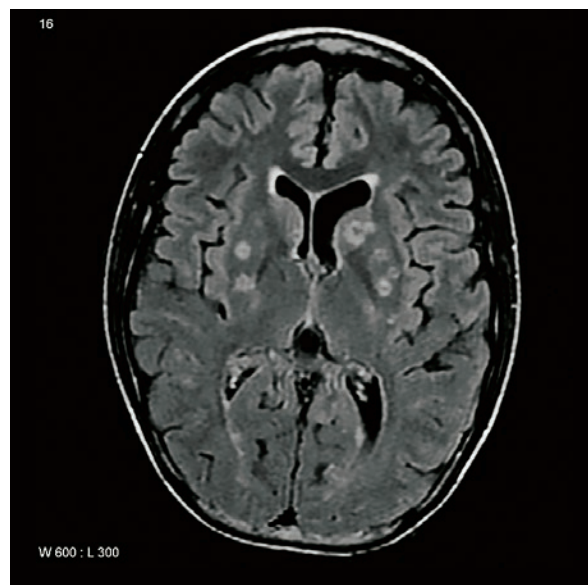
MRI, axial image of brain in FLAIR sequence, ring-enhancing lesions caused by toxoplasmosis infection (HIV patient).
